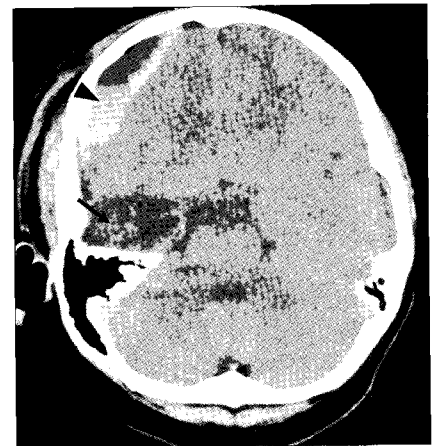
Axial CT scan showing an arachnoid cyst in the right temporal region (arrow) with epidural hematoma in the right frontal region (arrowhead).
